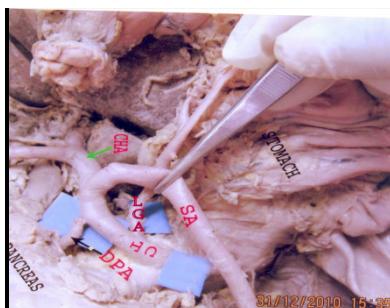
showing origin of dorsal pancreatic artery from the coeliac trunk. CT- Coeliac trunk, DPA- Dorsal Pancreatic artery, SA-Splenic artery, LGA- Left gastric artery, CHA-Common Hepatic artery
